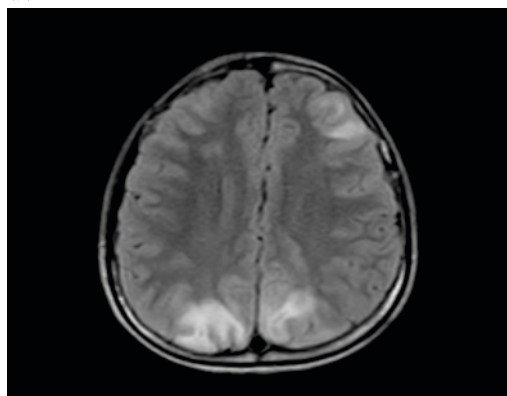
T2/FLAIR showing hyperintensity on the frontal and occipital area
